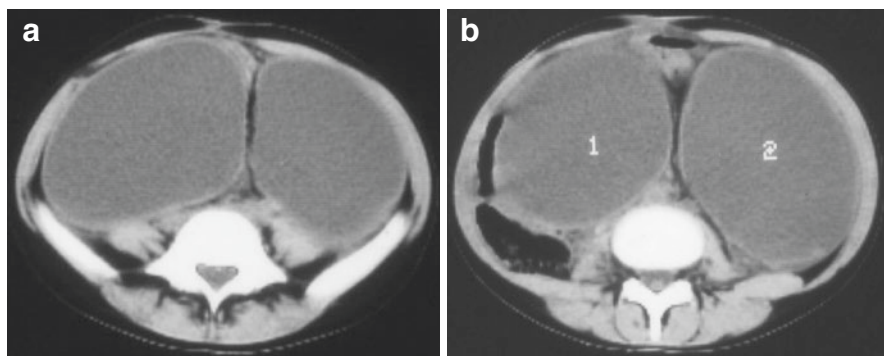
(a, b) Abdominal and pelvic CT-scans showing large bilateral ovarian teratomas
